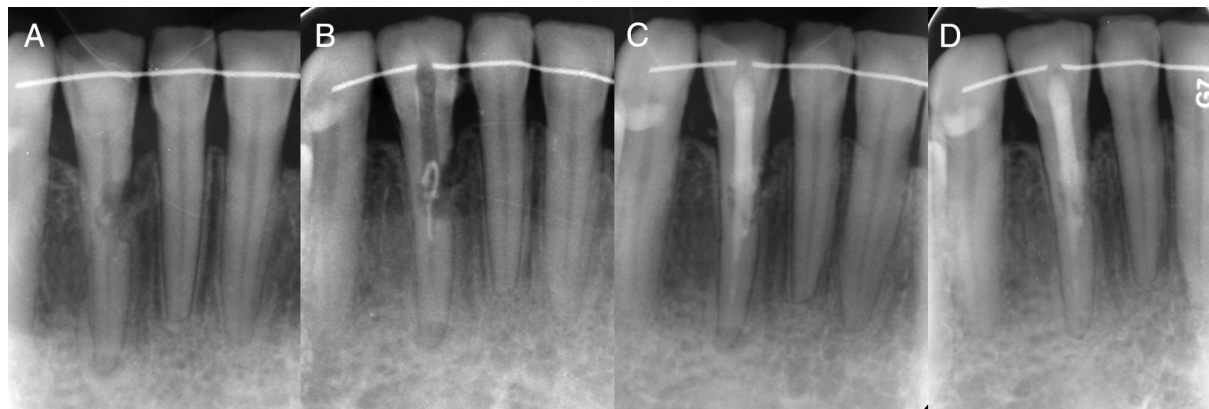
(A) A preoperative image of tooth #26 provided by the referring dentist. The radiograph shows class 4 ICRR in the coronal third and midroot area, perforation of the root because of resorption, a crestal bony defect adjacent to the perforation, and a small periapical lesion. (B) A preoperative image of tooth #26 at the initial visit. The access cavity prepared by the referring dentist left open to the oral cavity and radiopaque material in the root canal space determined to be a piece of gutta-percha. (C) A postoperative image of tooth #26 after the coronal restoration was performed. (D) The 24-month follow-up radiograph. Note that despite the presence of resorptive lacuna, there is no progression of the resorptive process; osseous healing of the crestal bony defect at the perforation site has occurred; and the periapical lesion has healed.
